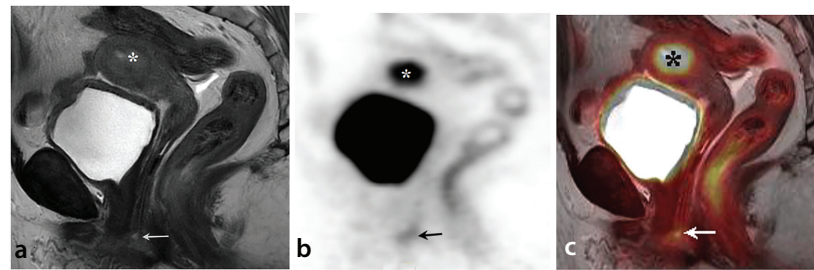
Infected Bartholin gland cyst. The sagittal T2-weighted magnetic resonance image (MRI) (a) shows a hyperintense small rounded lesion (arrow) compatible with a Bartholin cyst lying at the distal end of the vagina in a patient with endometrial cancer (asterisk). Its location below the level of the pubic symphysis is typical. The sagittal positron emission tomography (PET) (b) and sagittal fused PET/MRI (c) show a tiny focus with fluorodeoxyglucose (FDG) uptake (arrows) in the distal vagina, suggesting that it is infected. Asterisks in (b) and (c) indicate intense FDG accumulation in endometrial cancer.
